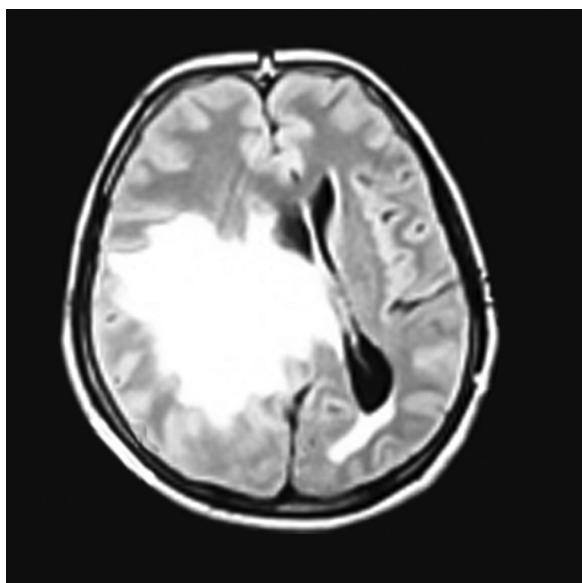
Magnetic resonance imaging revealed a contrast enhanced right parafalcine mass (5.5 cm × 5.8 cm) causing mass effect with midline shift toward the left.
